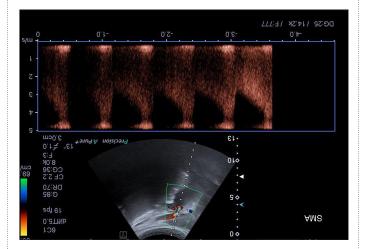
Duplex ultrasound examination of the superior mesenteric artery showing broadening of the arterial waveform with a peak systolic velocity in excess of 4m/s. There is aliasing artifact indicating that the true peak velocity may be even higher. These findings are consistent with critical vessel stenosis
